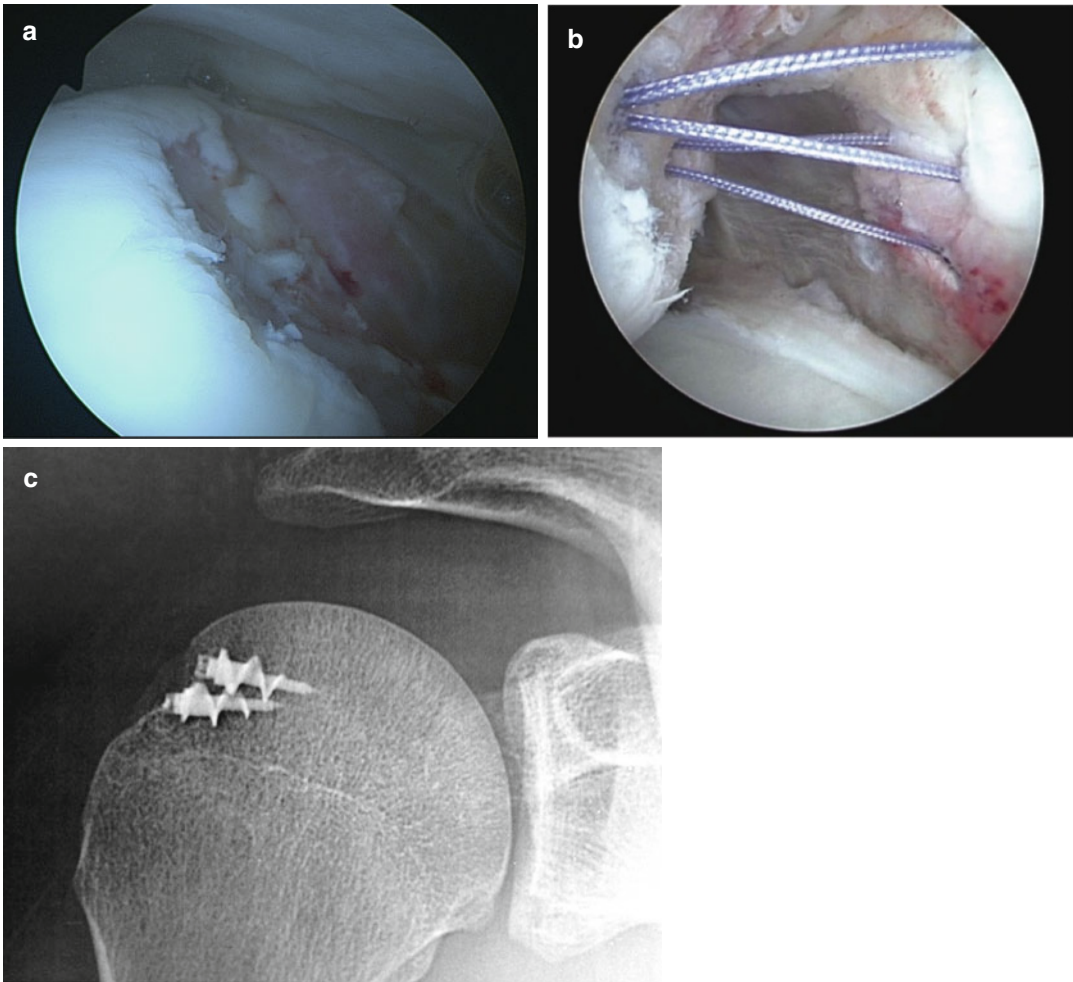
Arthroscopic remplissage technique. (a) Hill-Sachs lesion preparation. (b) Double pulley with anchors. (c) Radiograph with two anchors fixing the infraspinatus tendon
